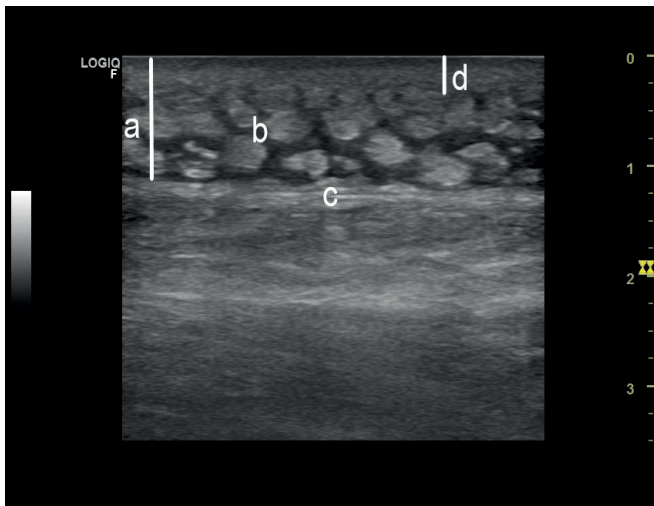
Ultrasonographic sign of necrotizing fasciitis at the initial stage with early skin manifestation
